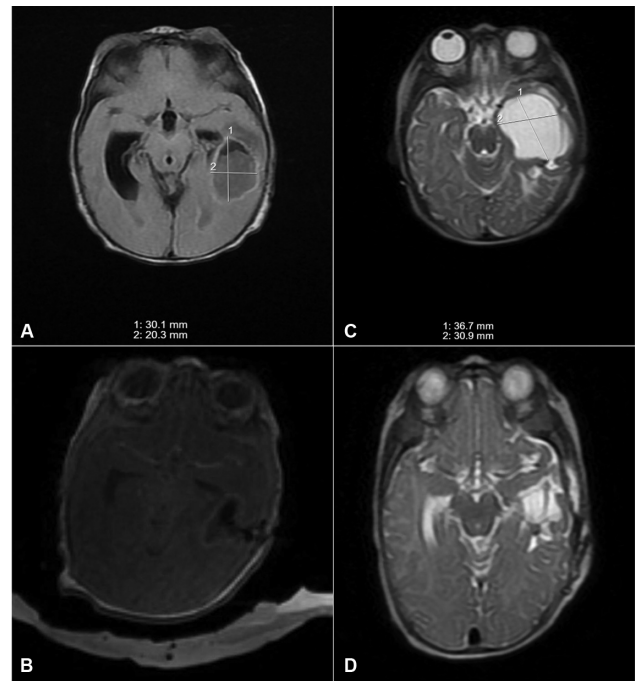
Serial brain magnetic resonance imaging showing: (A) Left temporal lobe abscess (30.1 mm \times 20.3 mm) and bilateral ventriculomegaly on day of life 15. (B) Decompression of the left temporal lobe abscess via a left temporal burr hole and decreased ventricular size following external ventricular drain placement via a right frontal burr hole on day of life 16. (C) Increased size of the trapped temporal horn of left lateral ventricle (36.7 mm \times 30.9 mm) on day of life 69. (D) Decrease in size of the temporal horn of left lateral ventricle following placement of left frontal ventriculoperitoneal shunt and revision with placement of a catheter into the left temporal horn cyst on day of life 104.
